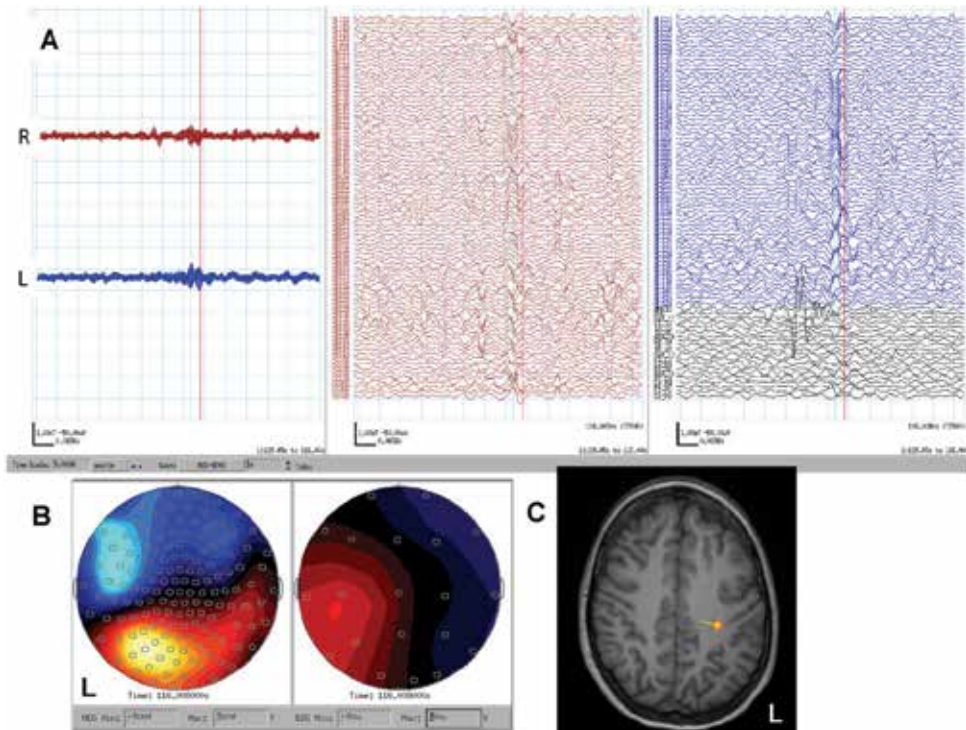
The second peak of MEG polypsikes. A, MEG shows polypsikes. The red cursor is placed on the EEG spike peak which corresponded to the second peak of the MEG polypsikes. B, magnetic field topography (left) and EEG topography (right) at the EEG spike peak (red cursor on A). C, MEG dipole at the second peak of polypsikes is localized to the left Rolandic region on MRI, lateral to the first peak dipole source (Fig. 3C). It is noted that the dipole orientation and magnetic field topography are in the opposite direction from those of the first dipole (Fig3. C).
